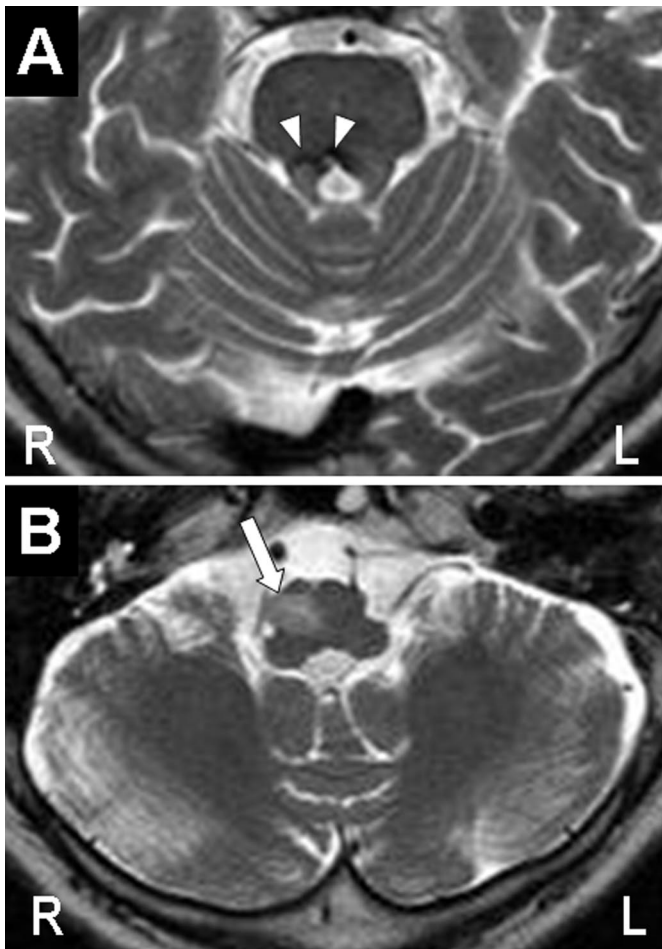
Brain T2-weighted MRI on admission. (A) Old small hemorrhage in the right pontine tegmentum (arrowhead). (B) The hypertrophic olive on the right side of the medulla (arrow).
